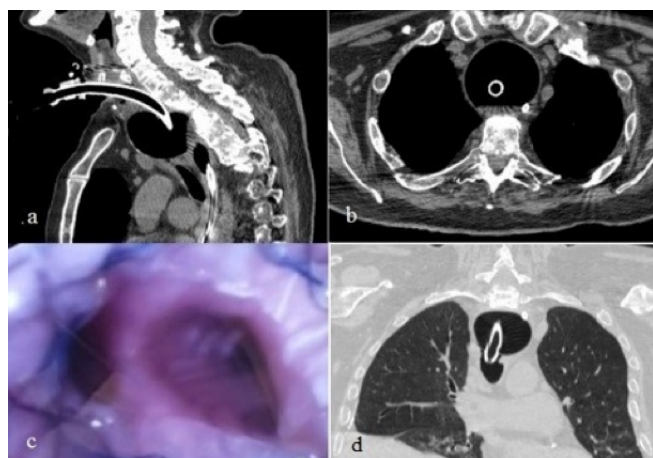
Thorax CT images of case 4, c. bronchoscopic image of the distal trachea.
